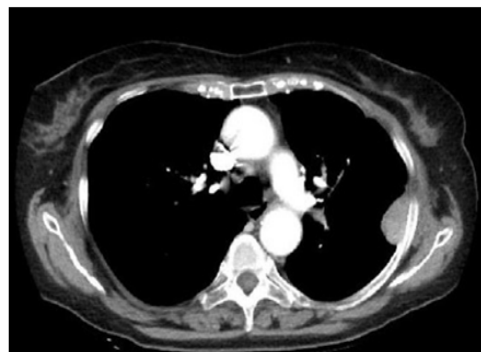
CT-Scan. Pleural nodulations on the left side.
